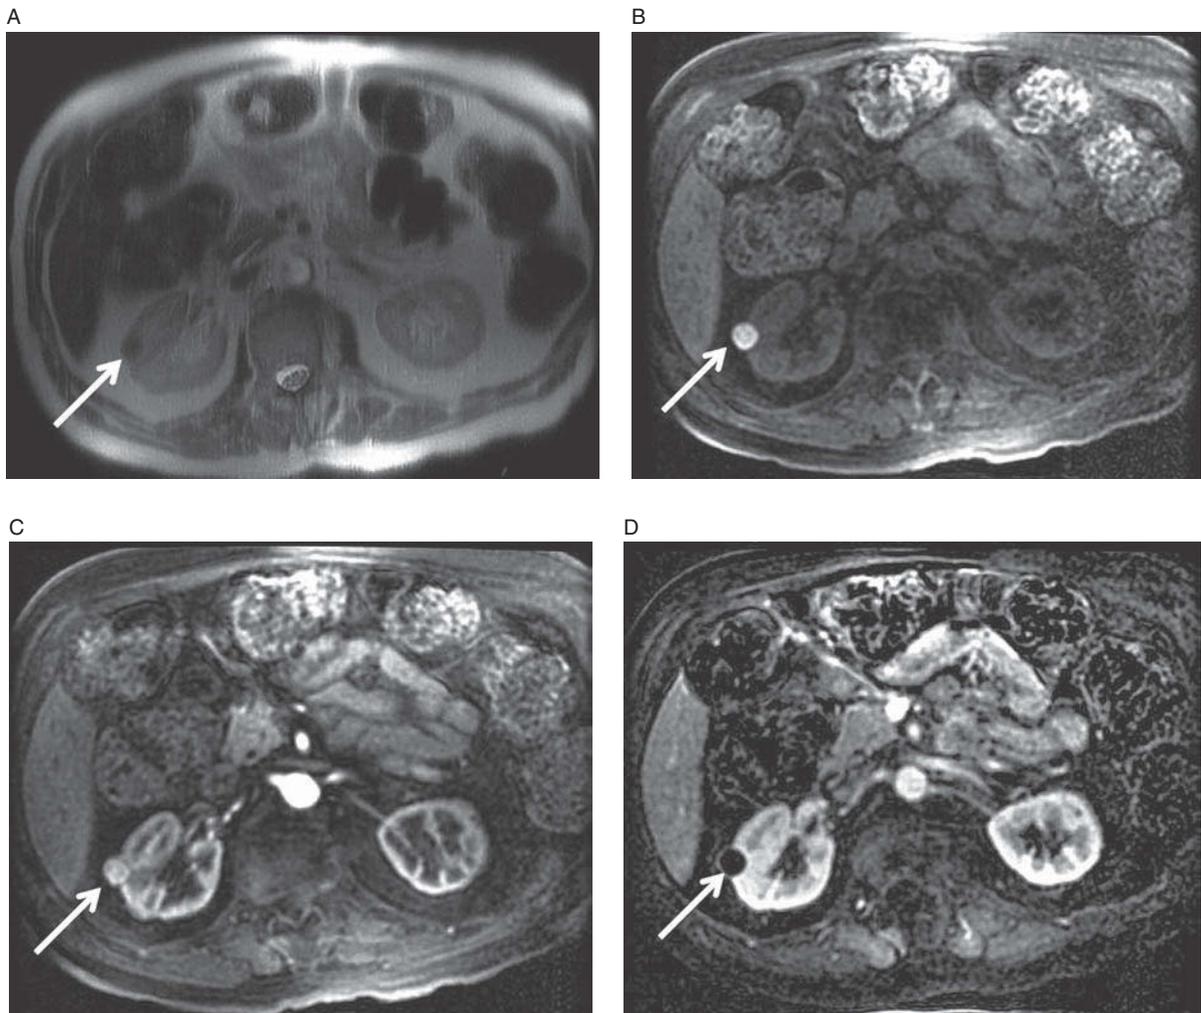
Complex renal cyst. Axial T2-weighted image (A) shows a small, T2-dark lesion within the upper pole of the right kidney. Axial T1-weighted, fat-saturated pre-contrast image (B) demonstrates homogeneous T1-bright signal. If all you had was post-contrast image (C) you might think this was a solidly enhancing (and therefore malignant) mass. But, we know that the lesion was bright before contrast administration. So, we check our subtracted image (D) and see that the lesion is black – there is no true enhancement. This is a complex (proteinaceous or hemorrhagic) cyst.
